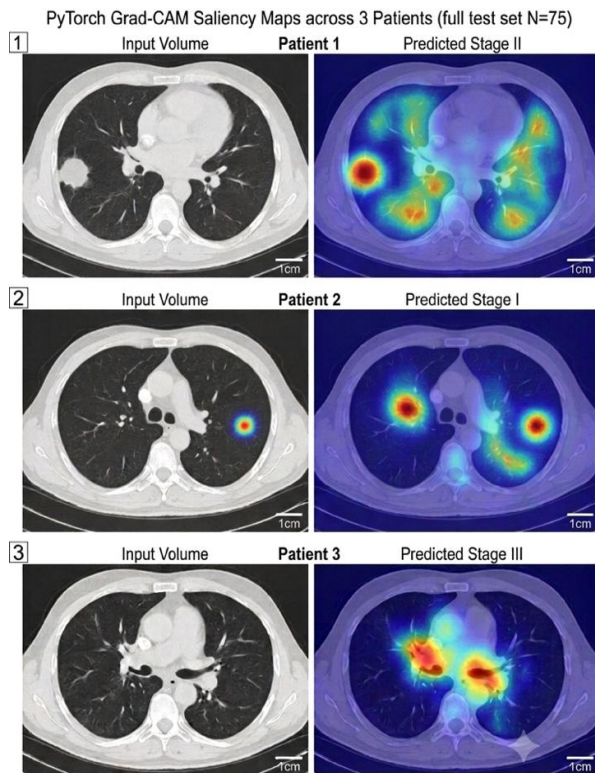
Grad-CAM saliency maps for three test cases (Patients 1–3; predicted Stages II, I, III), each CT slice shown beside its Grad-CAM activation from the 3D ResNet-18. Activations are diffuse, in contrast to the case-level evidence from the CBR module.
